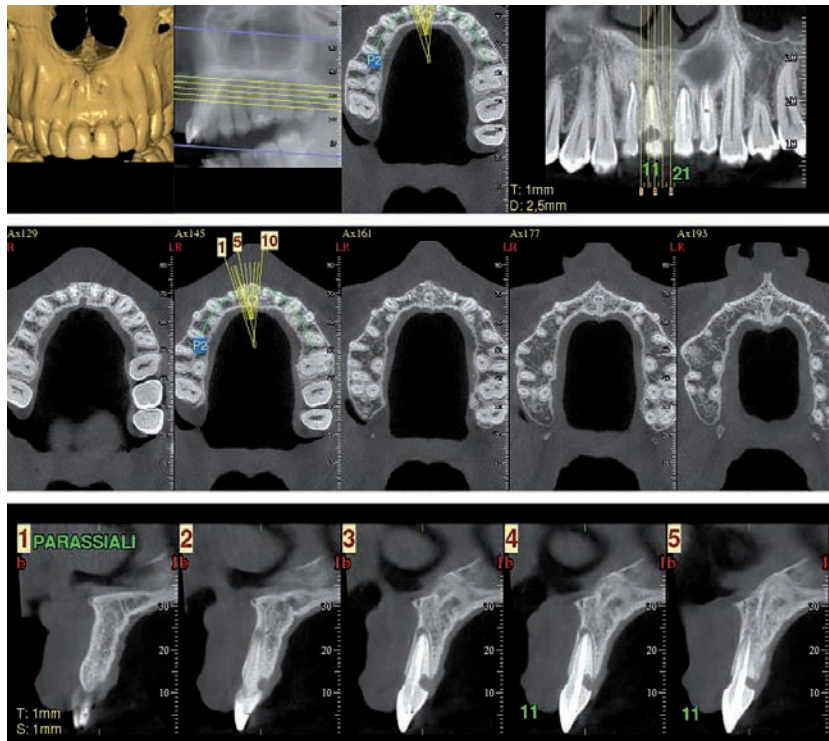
CBCT scan of an upper arch, the root canal anatomy of all the teeth is clearly visible in the coronal sections. The right first incisor presents an external cervical resorption that is localized in the palatal side of the root. In the sagittal sections view the extension of the pathological process is clearly seen.
